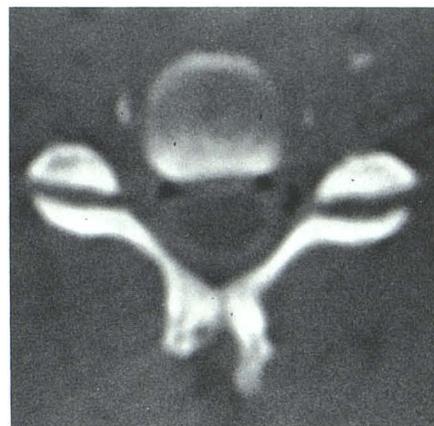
CT scan in case of bilateral distracted C5-C6 facet joints without articular pillar fracture. Pluridirectional tomogram (not shown) confirmed distraction and demonstrated no fracture.
